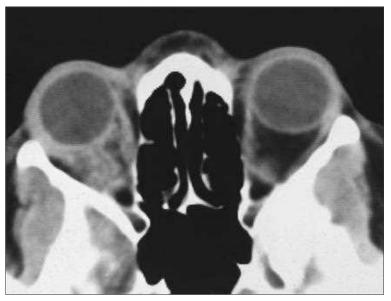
CT Scan of a Metastatic Breast Carcinoma With an Irregular Mass in the Right Retrobulbar Orbit.
